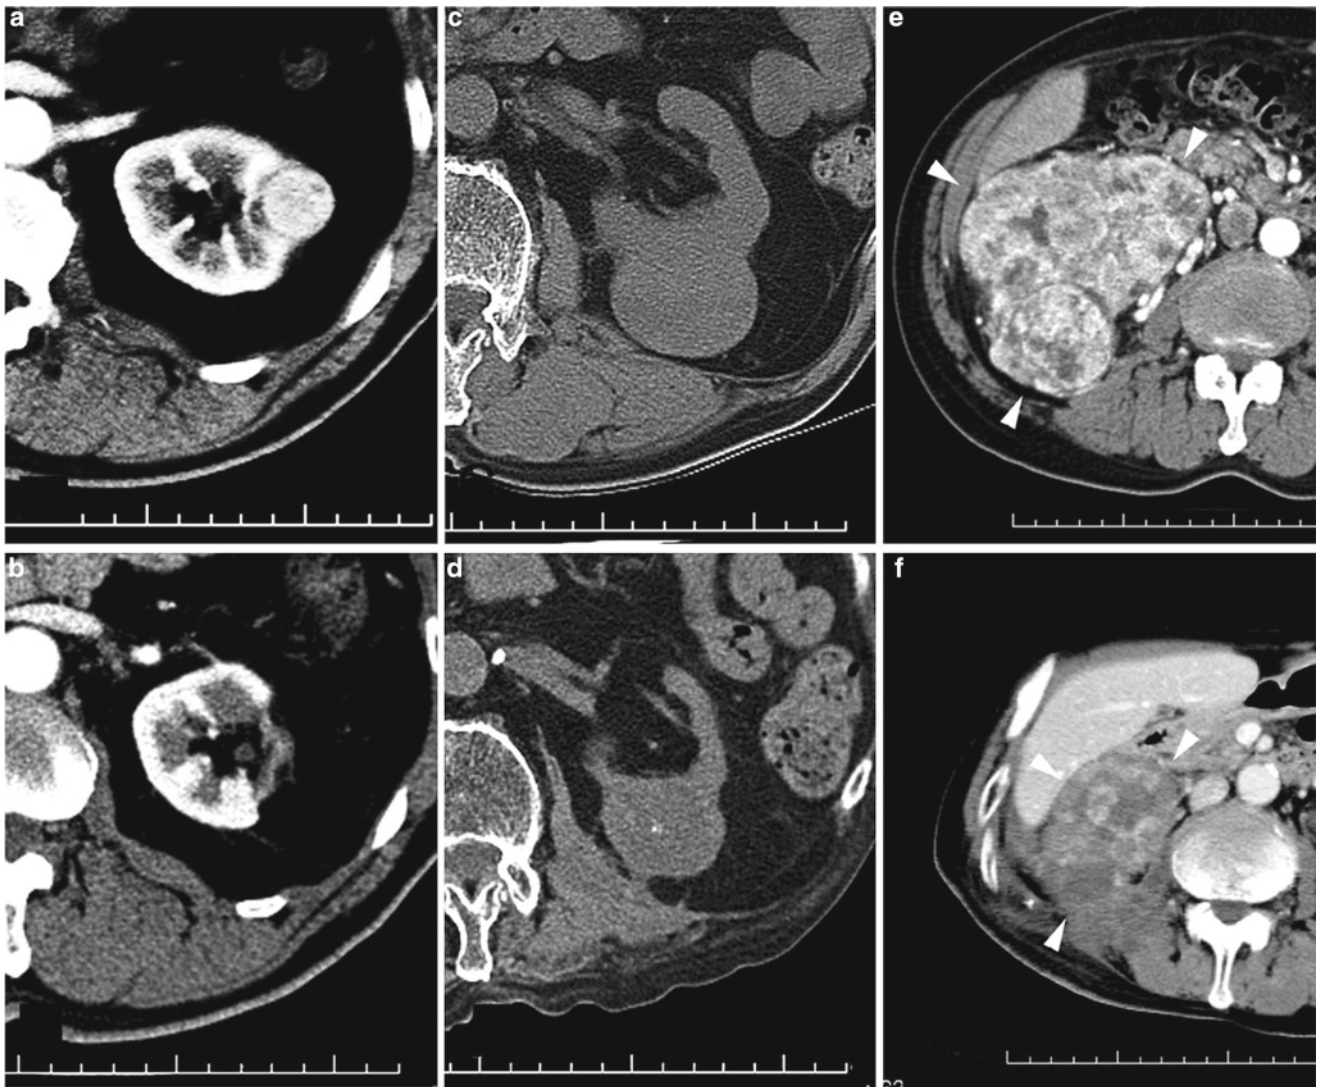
CT images before carbon ion radiotherapy (CIRT) (a) and 5 years after CIRT (b). CT images before CIRT (c) and 9 years after CIRT (d) in another patient, showing that the tumor had been shrinking.
